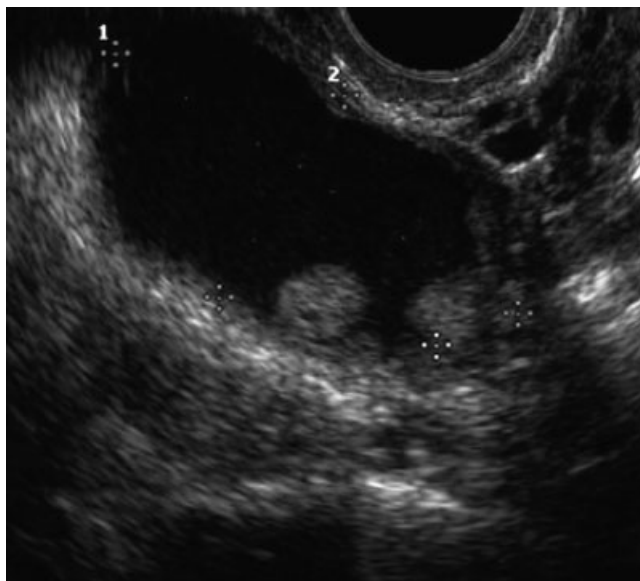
Transvaginal ultrasound image at 10 weeks' gestation showing two hyperechogenic papillary excrescences of the internal wall of the cyst in the right ovary.
